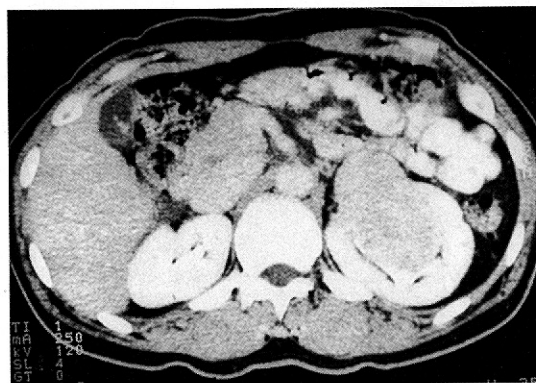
Computed tomography demonstrates a well demarcated highly enhanced tumor mass in the central portion of left kidney with expanding to the renal hilum.
